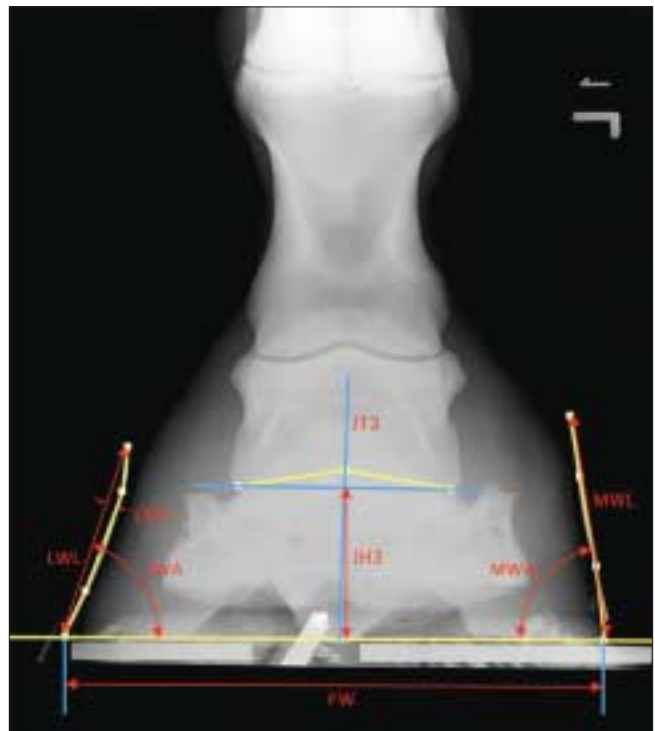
Joint and hoof parameters of a dorsopalmar radiograph. LWL: Lateral wall length, from the hairline to the lateral distal hoof rim. LWA: Angle between the lateral wall and the ground. LWD: Lateral wall deviation, longest perpendicular distance from the LWL to the contour of the lateral hoof wall. MWL: Medial wall length, from the hairline to the medial distal hoof rim. MWA: Angle between the medial wall and the ground. MWD: Medial wall deviation, longest perpendicular distance from the MWL to the contour of the medial hoof wall (not measurable in this radiograph). FW: Foot width, distance between medial and lateral hoof rim. JH3: P2-P3 Joint Height, vertical distance between the ground and the blue line connecting the most medial and most lateral aspect of the P2-P3 joint. JT3: P2-P3 Joint Tilt, Angle between the perpendicular line to the ground and the perpendicular line to horizontal blue line connecting the most medial and most lateral aspect of the P2-P3 joint.
